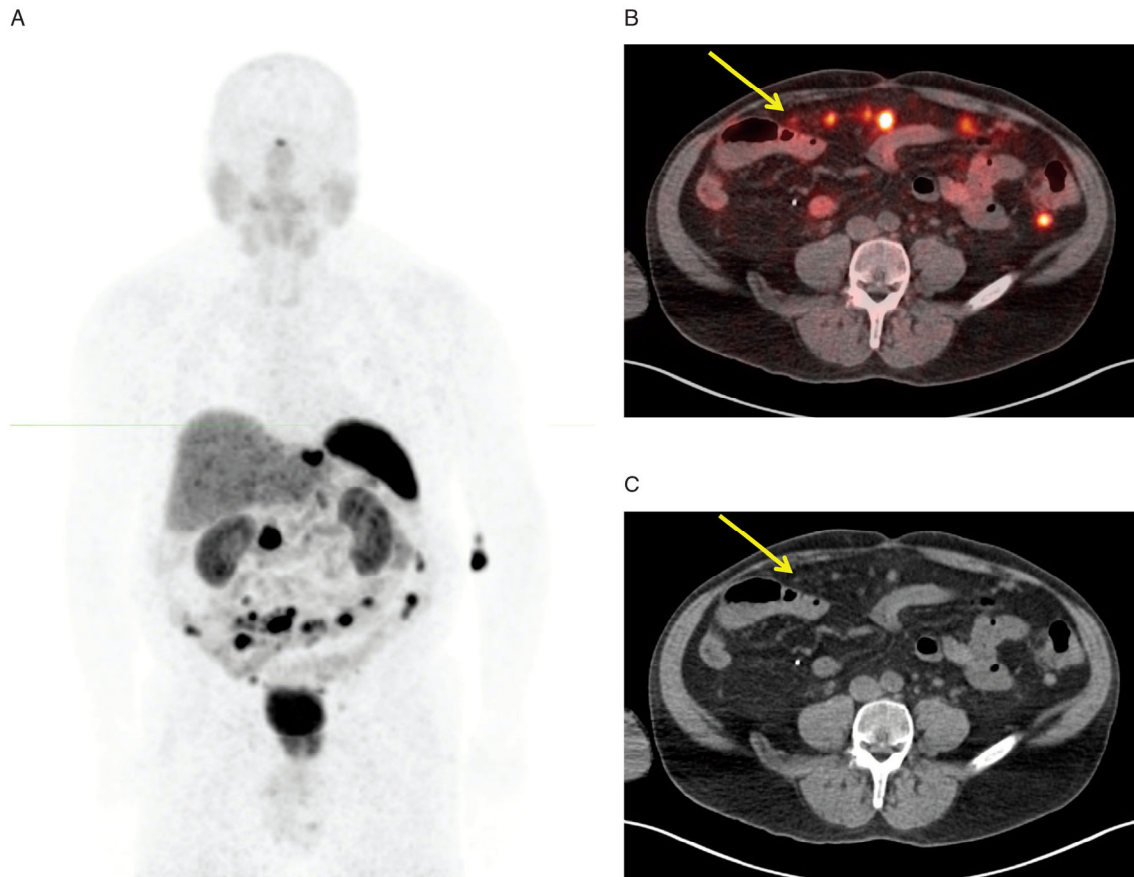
Maximum intensity projection image of a patient with metastatic small bowel carcinoid tumor (A). A small omental (yellow arrow) and peritoneal tumor implants are visible in the fused PET/CT (B) and corresponding CT (C) images. CT = computed tomography; PET = positron emission tomography.
